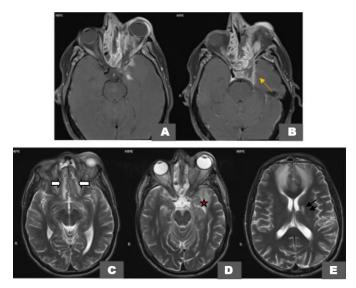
Axial T1-weighted plain images (A, B) showing diffuse fat stranding, minimal proptosis of the left globe (A). Infiltration of left cavernous sinus regions (B) (arrow). T2-weighted axial images (C–E) demonstrates bilateral basifrontal (C) (plain arrow), left mesial temporal (D) (star) encephalitis and striatocapsular and parietal hyperintense multiple spots (E) (double arrow).
